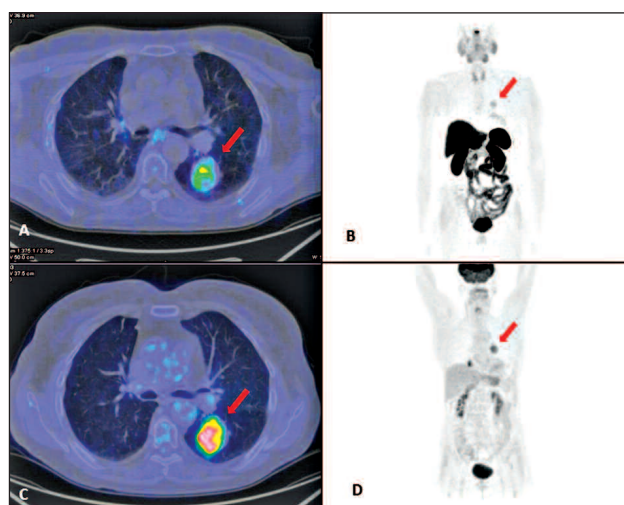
Radiometabolic pattern for AC. Increased uptake (A and B) and moderate or low uptake of radiolabeled somatostatin analogues (C and D) as studied by CT on the left and by ¹⁸F-FDG PET on the right side. (Images from IRCCS, Arcispedale, Santa Maria, Nuova, Reggio, Emilia, Italy)
